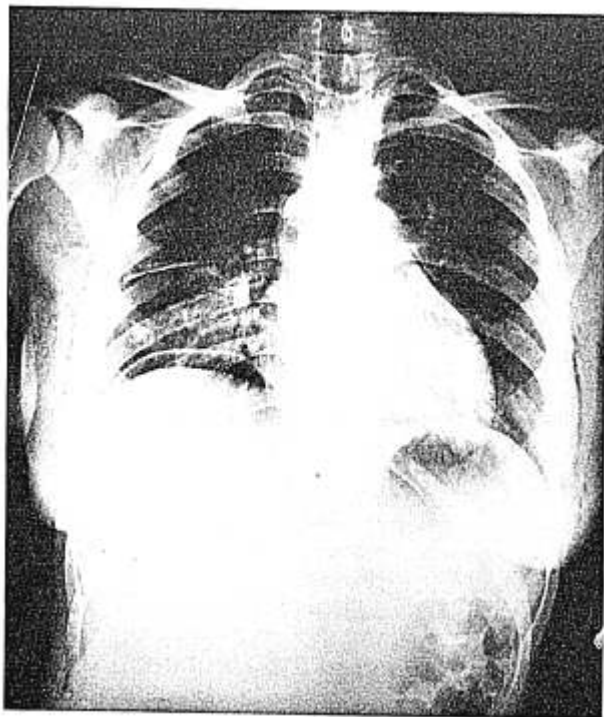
Chest x-ray reveals diffuse subcutaneous emphysema and gas in the peritoneum and in the pericardium related to CO₂ instillation at the time of arthroscopy.
